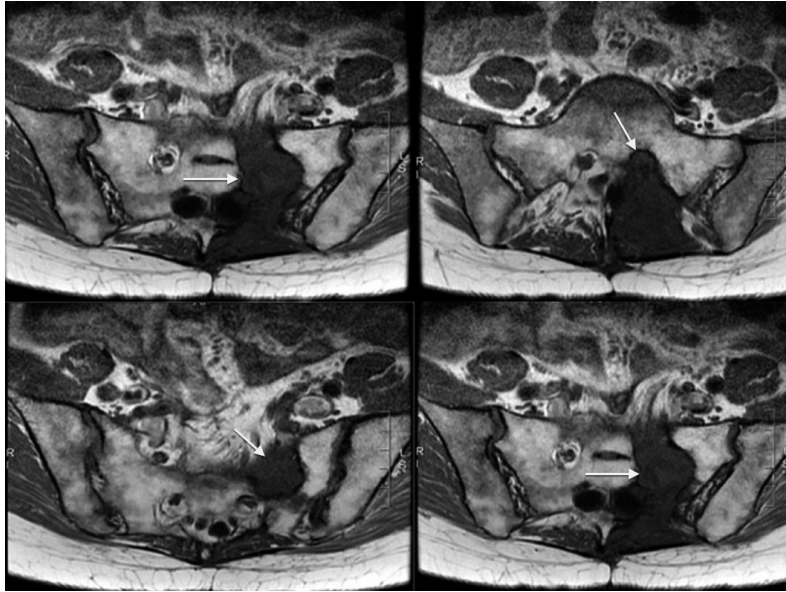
Postoperative axial magnetic resonance imaging with gadolinium demonstrating near complete tumor response (arrow) in the resection bed after radiation therapy.
